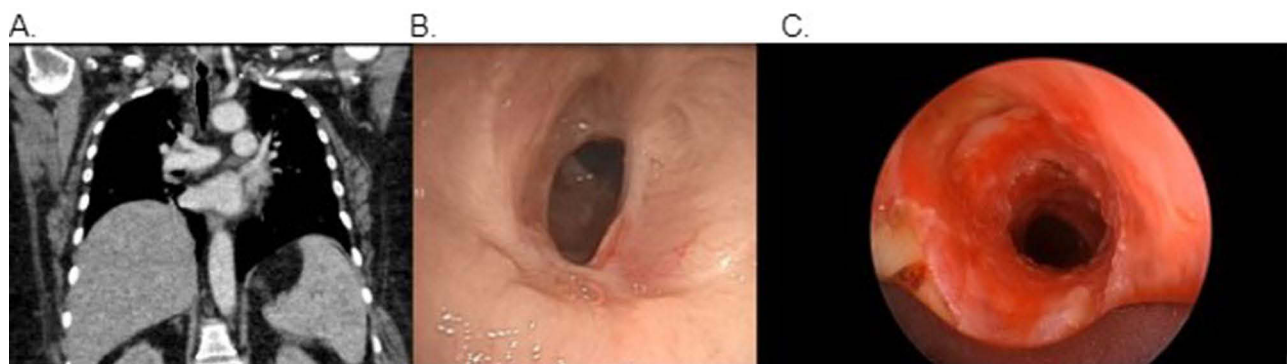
Grade 3, concentric, corkscrew-type stenosis seen on CT chest (A) and pre-dilation bronchoscopy (B). Post-dilation bronchoscopy reveals airway patency (C).
